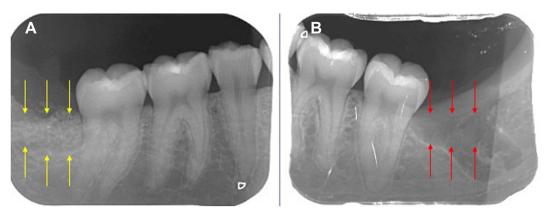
Periapical radiography (A) ATG placed on the test side (yellow arrows). (B) Ungrafted control side (red arrows). Sánchez-Labrador et al. Periodontal Healing in Bone Defects after Lower Third Molar Removal. J Oral Maxillofac Surg 2024.
